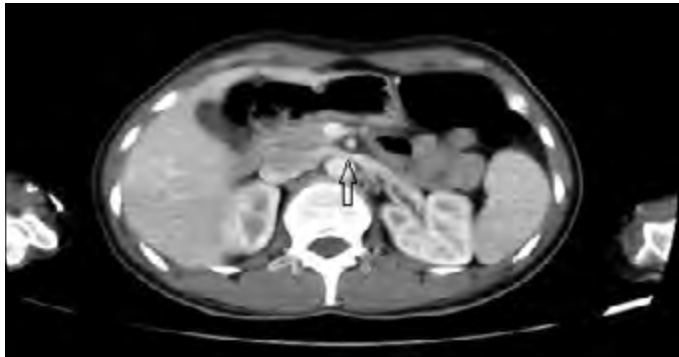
Computed tomography revealed compression of the left renal vein between the aorta and superior mesenteric artery
